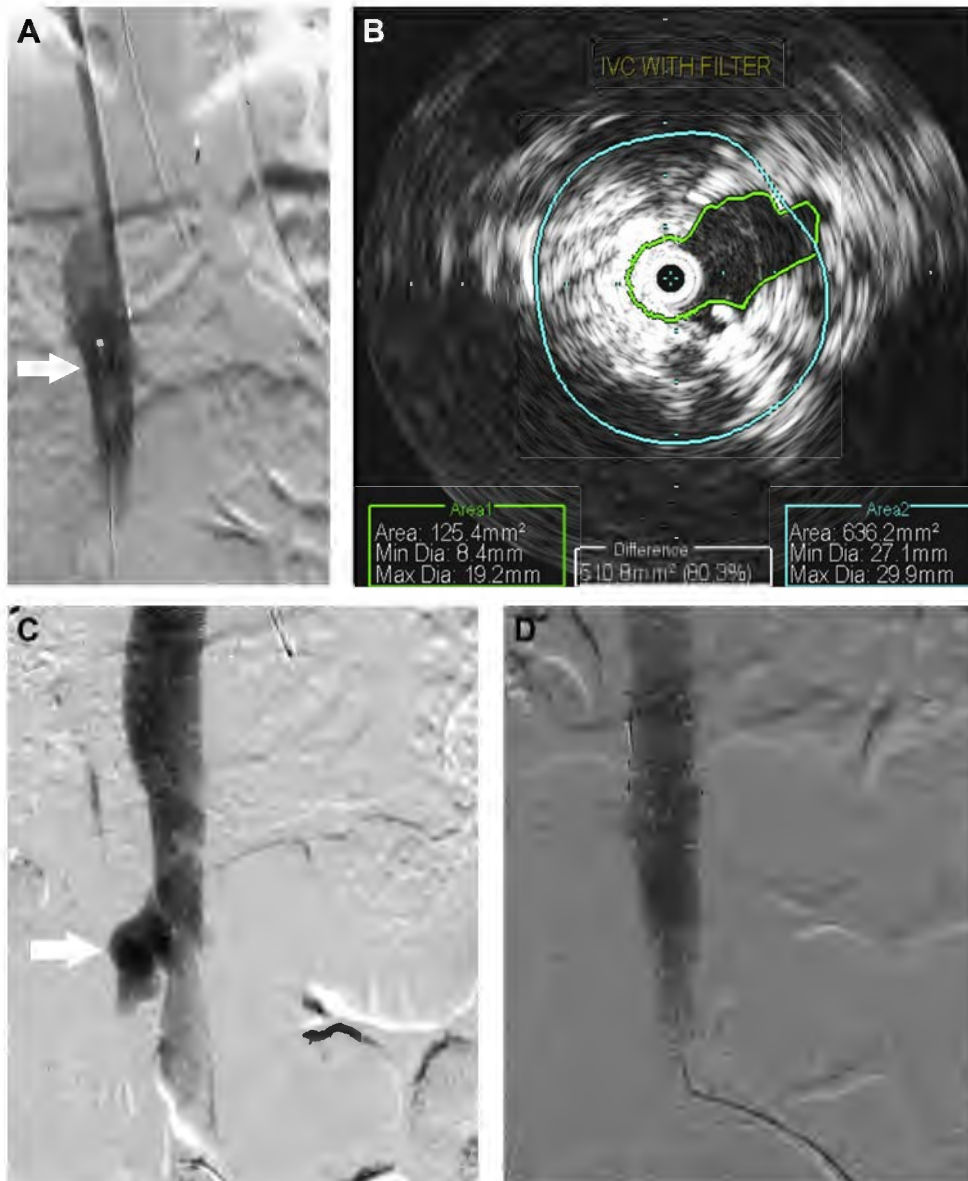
A, Inferior vena cava (IVC) filter seen in the infrarenal IVC (*white arrow*). Note that no obvious focal stenosis is readily apparent on the venogram. B, Intravascular ultrasound (IVUS) showed severe IVC stenosis at the level of the IVC filter resulting in outflow venous obstruction. C, After filter removal, a venogram of the IVC showed IVC perforation (*white arrow*). D, Cessation of contrast extravasation after stenting and sustained angioplasty.
